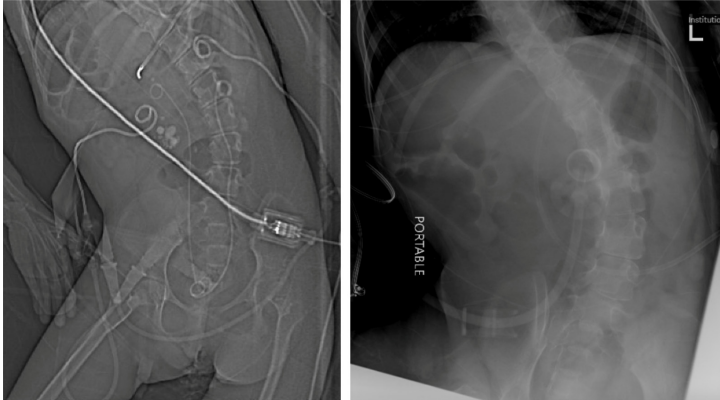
Representative preoperative CT scout imaging (left) shows large bilateral stones, bilateral encrusted ureteral stents, and bilateral nephrostomy tubes. Postoperative KUB (right) shows clearance of stone burden and removal of all urologic tubes.
